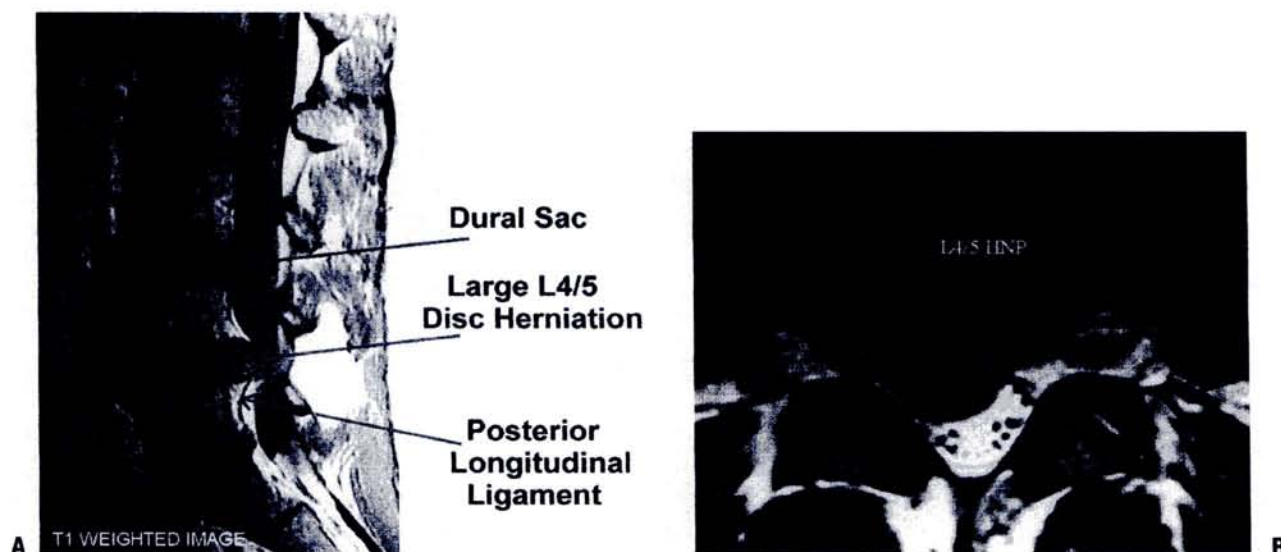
Lumbar microdiscectomy. MRI views of a large L4-5 disc herniation, sagittal (A) and axial (B). (From Koval KJ, Zuckerman, JD. *Atlas of Orthopaedic Surgery: A Multimedia Reference*. Philadelphia: Lippincott Williams & Wilkins, 2004.)
